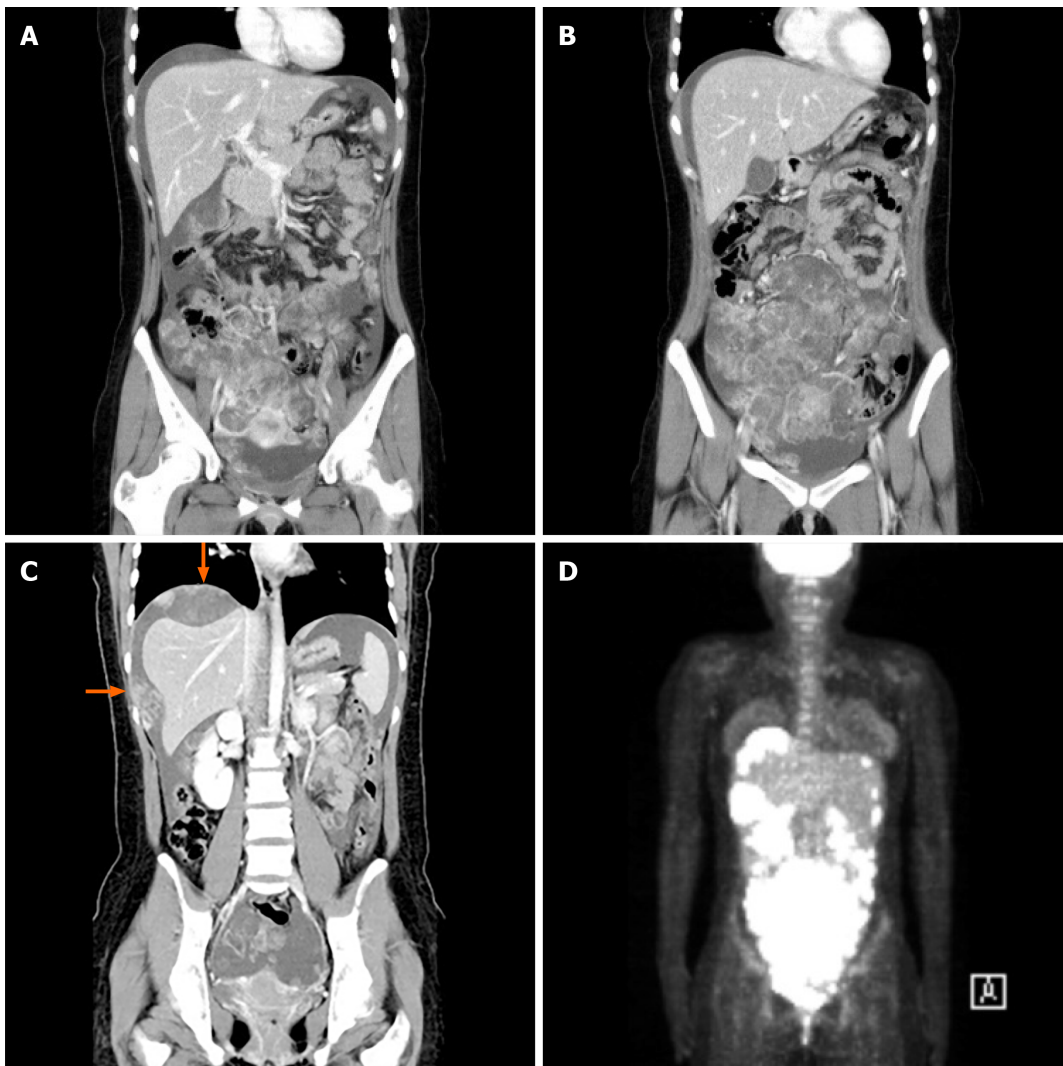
Imaging studies performed after hospitalization. A-C: Abdominal contrast-enhanced computed tomography reveals a large amount of ascites with multifocal irregular arterial enhancing masses and nodules in the right adnexa with uterus (A), omentum and mesentery (B), and diaphragm and peritoneal wall in perihepatic space (arrows) (C); D: Positron emission tomography-computed tomography reveals multifocal hypermetabolism that spread extensively in the peritoneal cavity.
